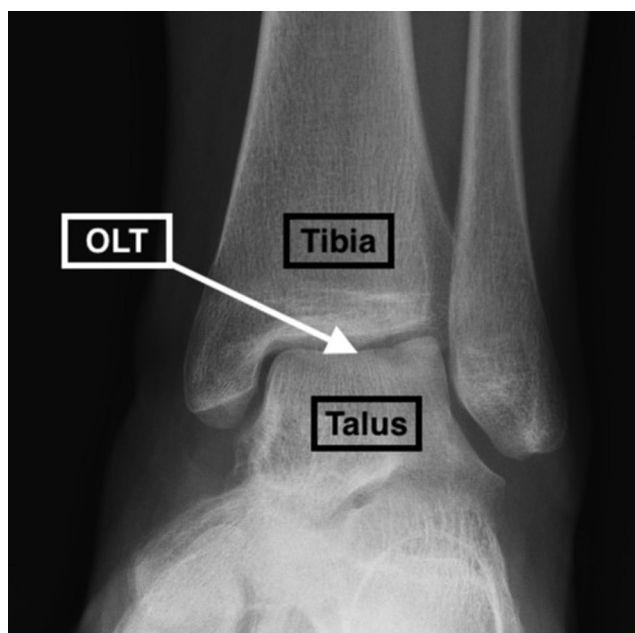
Anteroposterior radiographic view of left ankle showing osteochondral lesion of lateral talus (OLT).
